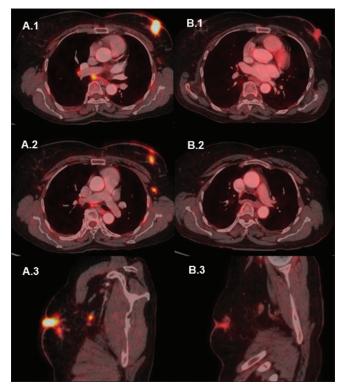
A 60-year-old female was diagnosed with carcinoma left breast - cT4bN1M0, estrogen receptor-positive, progesterone receptor-negative, human epidermal receptor 2 neu negative, and Ki67 25% (Luminal B type). She was planned for neoadjuvant chemotherapy and received four cycles of 3-weekly adriamycin and cyclophosphamide followed by 12 cycles of weekly paclitaxel. The initial staging positron emission tomography-computed tomography (PET-CT) images show fluorine-18 fluorodeoxyglucose accumulation in the primary lesion in the left breast infiltrating the nipple-areola complex with mildly thickened adjoining skin (A.1) and left axillary nodal disease (A.2), also seen in sagittal section (A.3). The postchemotherapy PET-CT showed partial resolution of metabolic activity in the primary lesion (B.1) and left axillary nodes (B.2), also depicted in sagittal images (B.3). The PERCIST grading is suggestive of partial metabolic disease, whereas the NIMS grading system (Grade 9) is suggestive of stable disease
